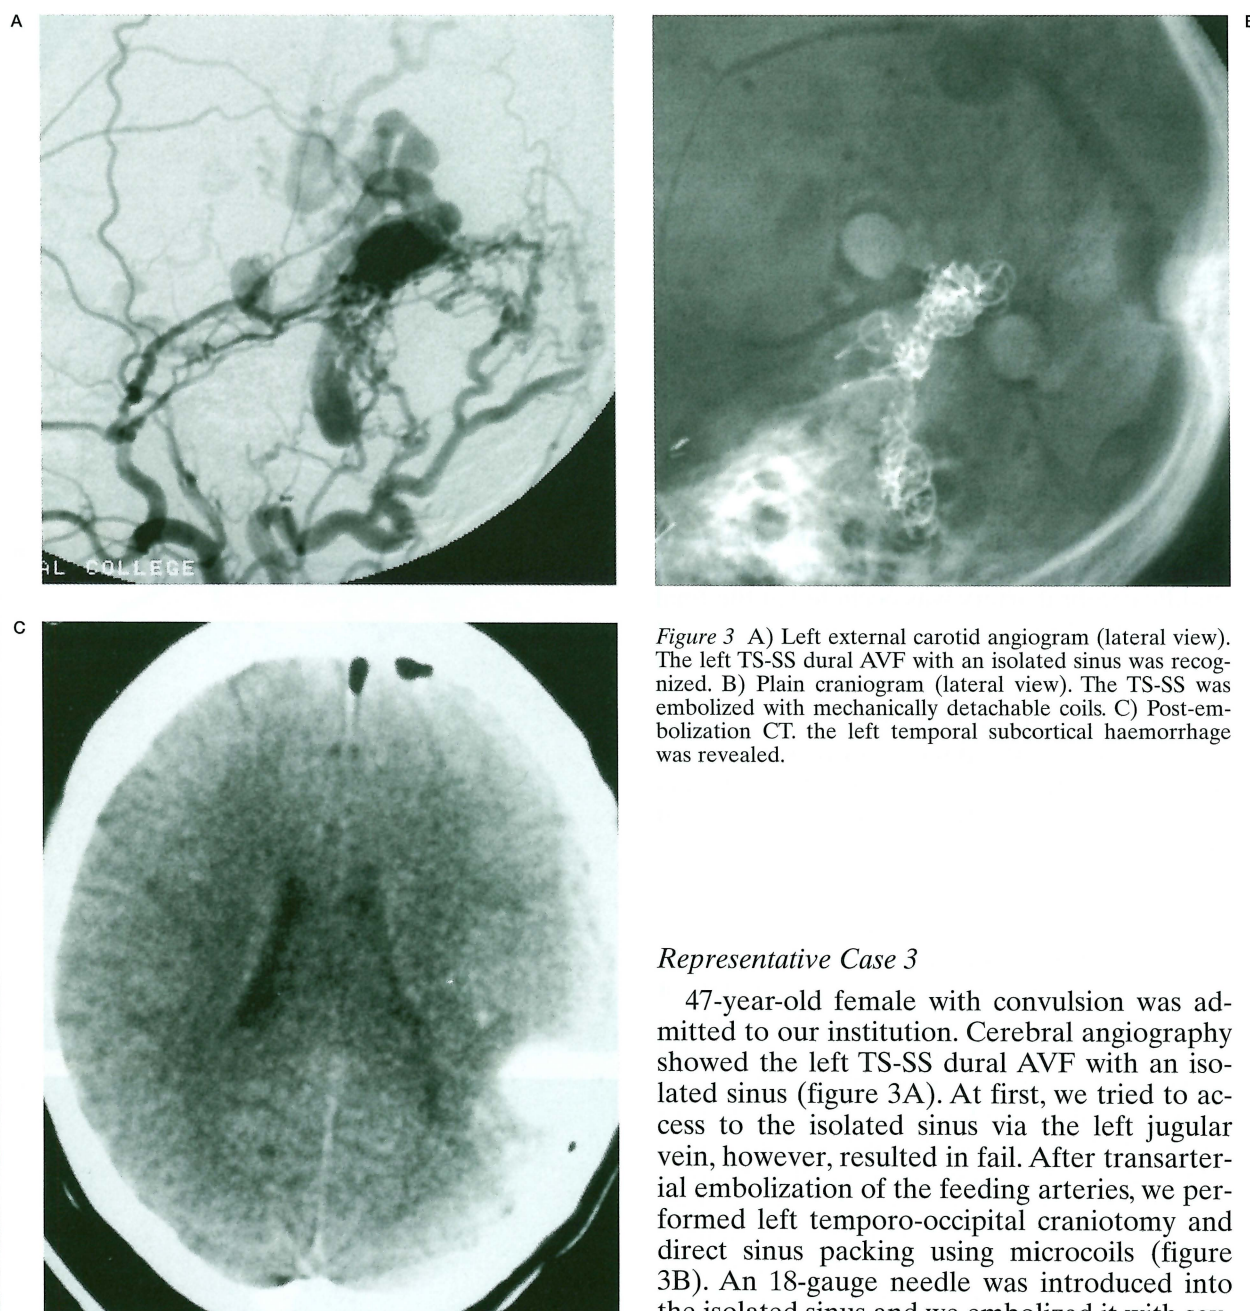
A) Left external carotid angiogram (lateral view). The left TS-SS dural AVF with an isolated sinus was recognized. B) Plain craniogram (lateral view). The TS-SS was embolized with mechanically detachable coils. C) Post-embolization CT. the left temporal subcortical haemorrhage was revealed.
